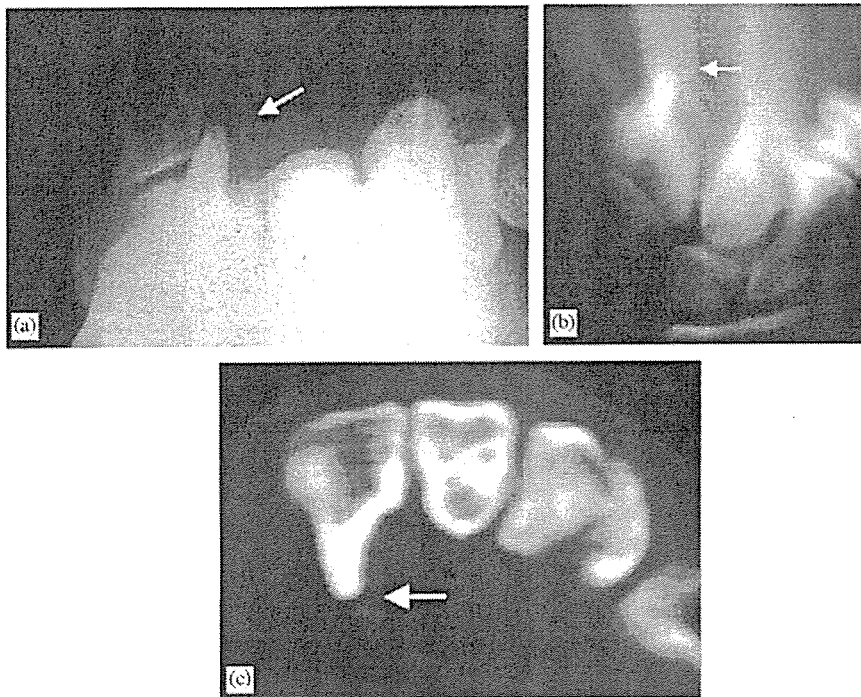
Non-union of the tip of the hook of the hamate bone: (a) on carpal tunnel view X-ray, (b) on tomography, and (c) on CT scan (case 2).
